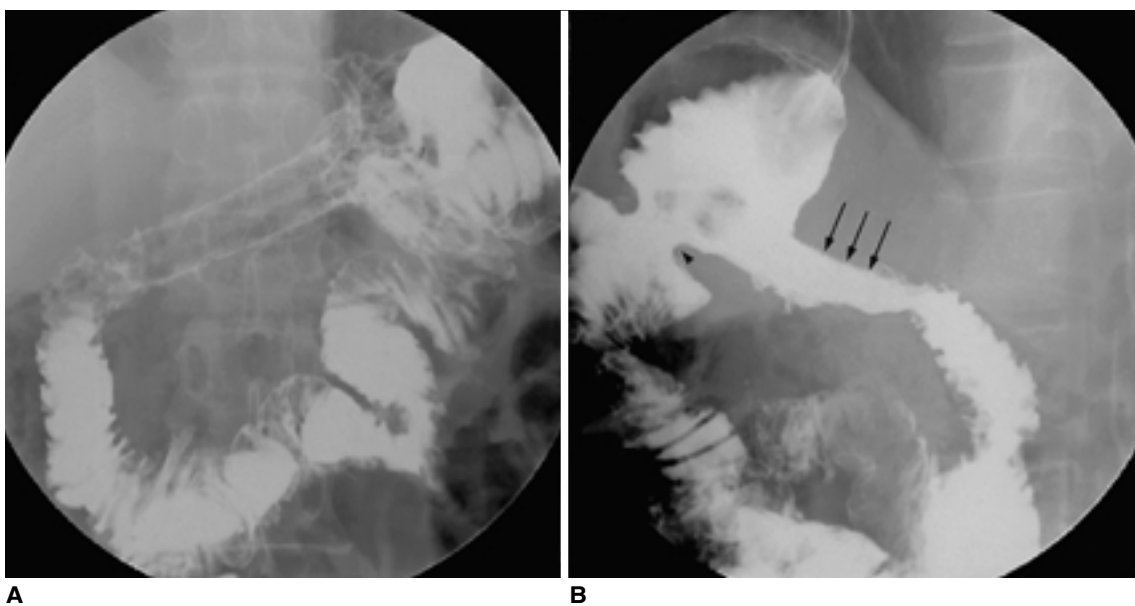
UGI radiographs after 2.5 months following stent placement show (A) the stent without complication such as migration, reocclusion or contrast leakage, and (B) good patency at gastroduodenostomy (arrows) and gastrojejunostomy (arrowhead).
